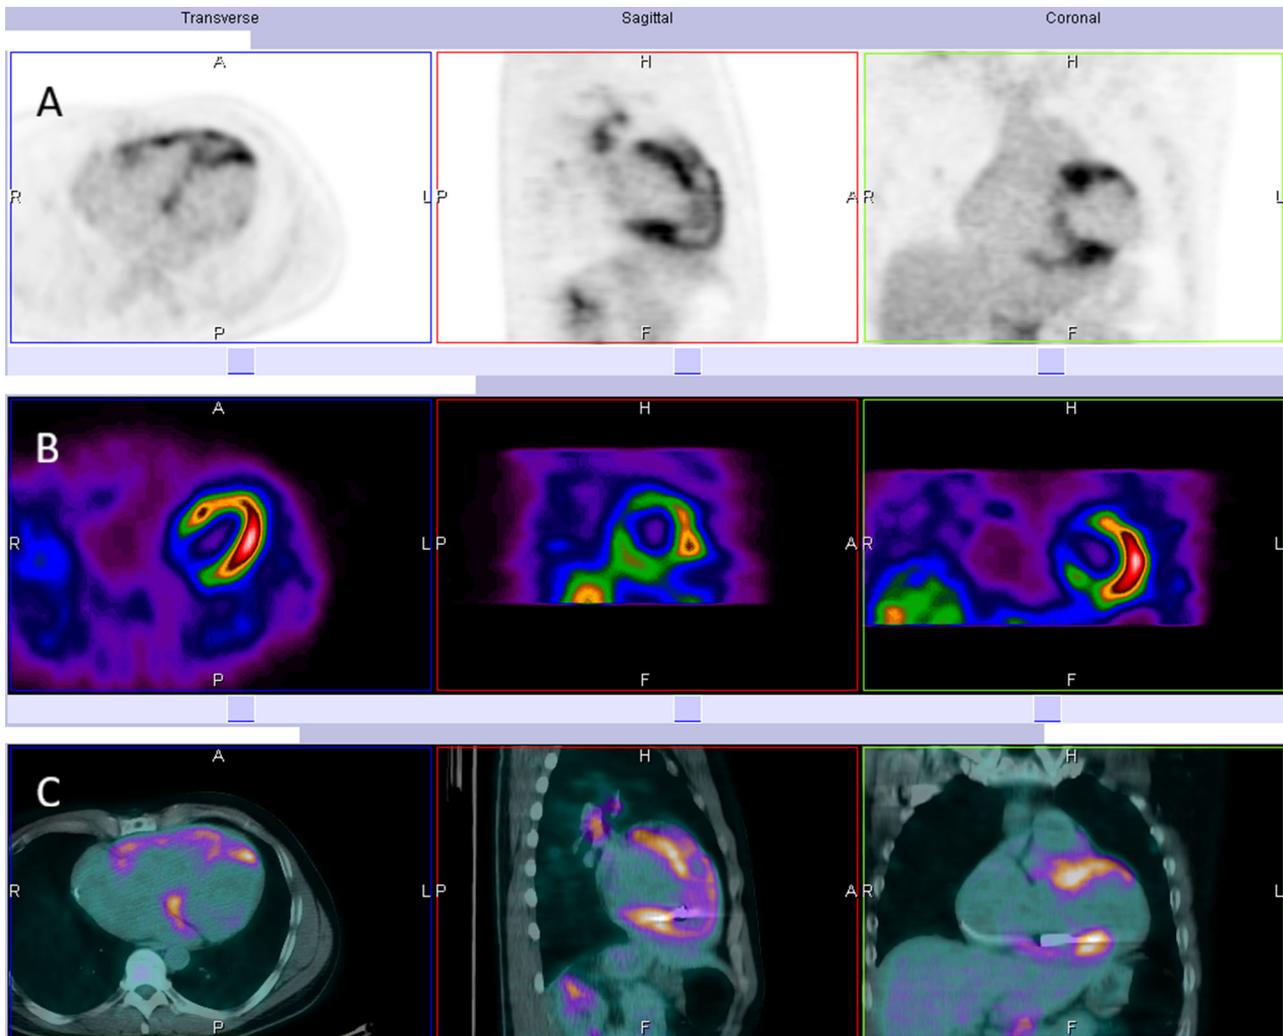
PET/Tc-99m sestamibi SPECT fused images. PET scan (A) showed FDG uptake in the LV apex, interventricular septum and RV free wall. SPECT images (B) showed a reduction in myocardial perfusion in the corresponding regions. In the setting of normal coronary angiography (excluding hibernating myocardium as a question), the metabolism-perfusion mismatch is suggestive of cardiac sarcoidosis. C Shows the PET-CT fused images.
